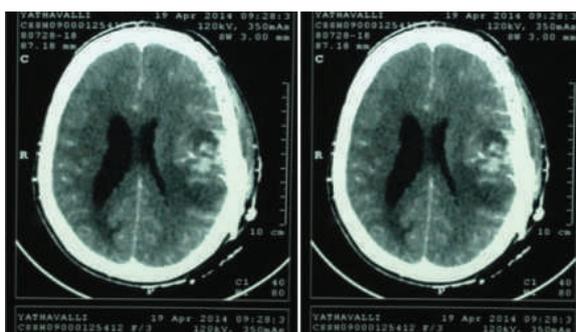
Post-operative CT brain (contrast) showing post-operative changes with tumor bed hematoma and no residual tumor.
